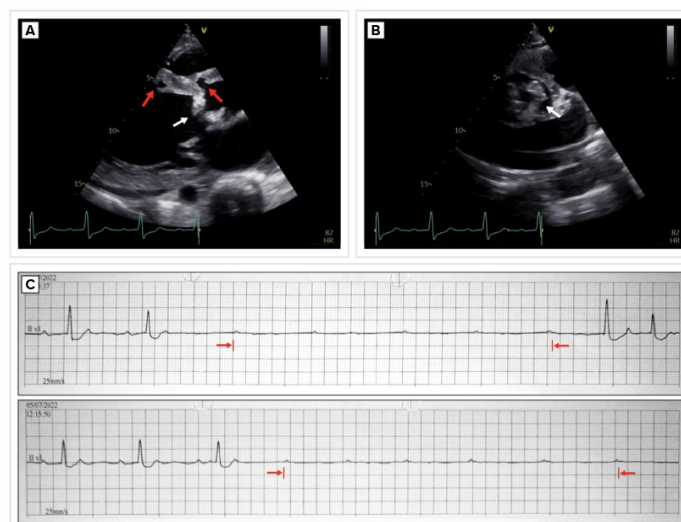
Parasternal long axis view on TTE revealing an aortic valve vegetation (white arrow) and interventricular septum abscess along with annular aortic abscess (red arrow) (A); Parasternal short axis view on
